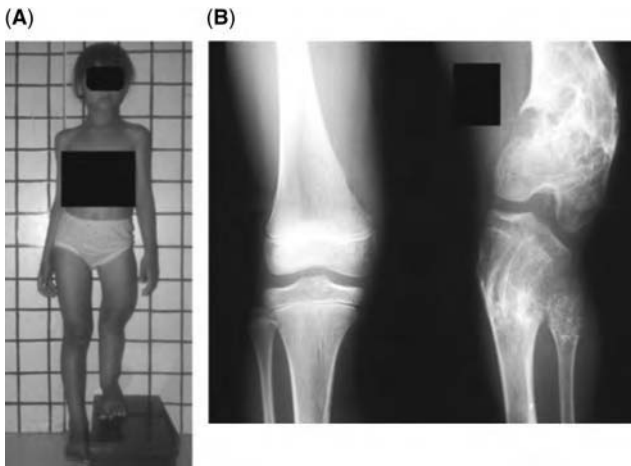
(A) Photograph of an 11-year-old girl taken at the onset of the disease. The patient presented with a lower limb discrepancy on the left of 18 cm, a varus and antecurvatum deformity of the femur, and an externally rotated valgus tibia with retro-curvatum. (B) Initial radiograph showing shortened femur and tibia on the left and chondromas (in the proximal and distal femur as well as in the tibia).
